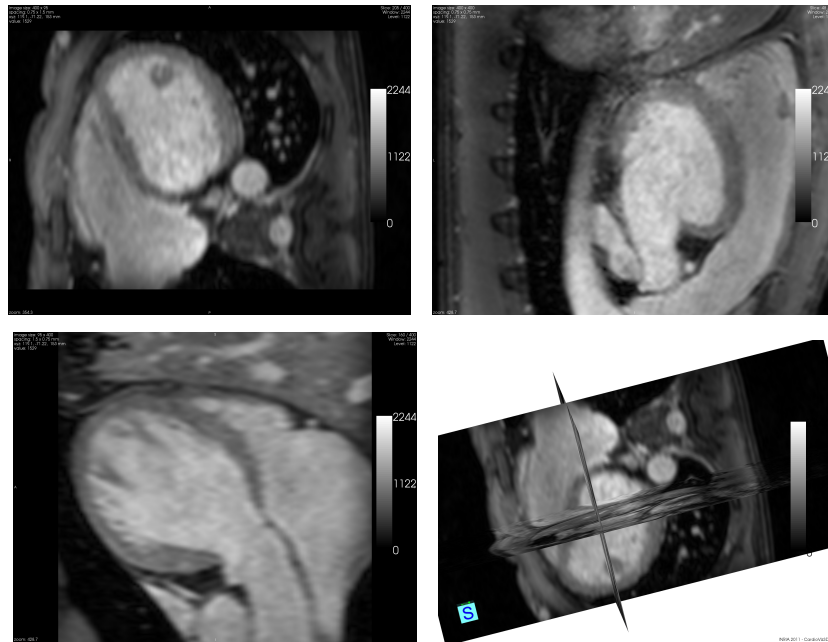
Example of static 3D SSFP MR images. Top Left: view with resolution 1.5 mm x 0.75 mm; Top Right: view with resolution 0.75 mm x 0.75 mm; Bottom Left: view with resolution 1.5 mm x 0.75 mm; Bottom right: 3D view.
